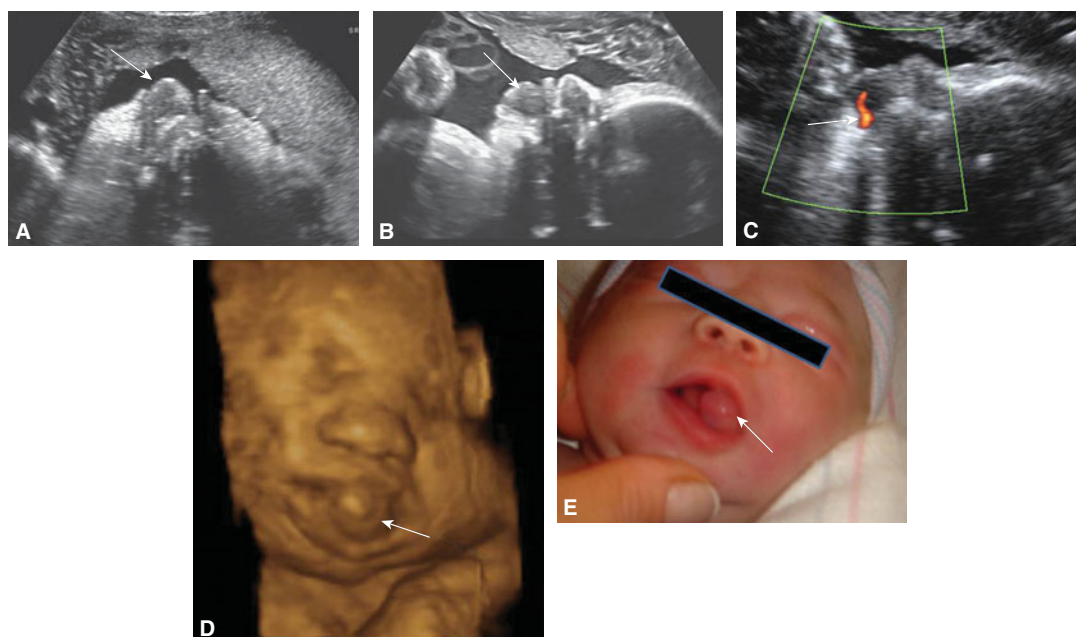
2D and 3D evaluation of epignathus arising from the left lower lobular. Arrows show the mass. (A) Axial section. (B) Parasagittal section. (C) Vascular supply by power Doppler. (D) 3D surface rendering. (E) The neonate at birth (From Bornstein E, et al.⁵⁵ 2009, with permission).
